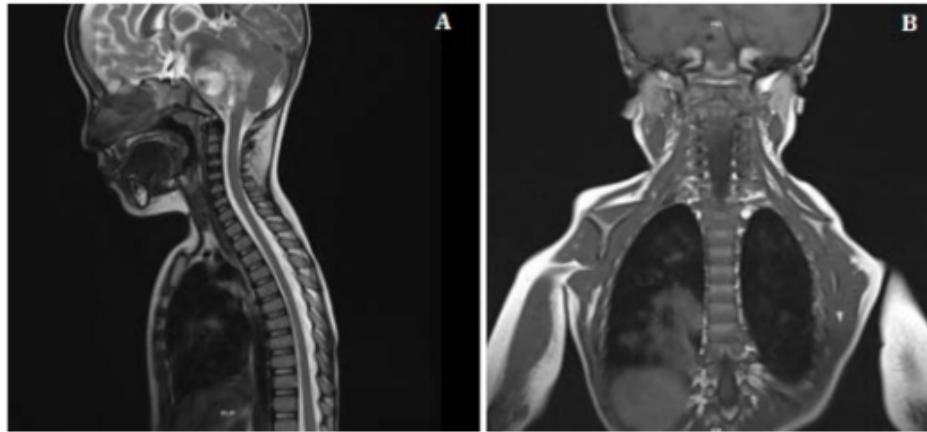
Postoperative contrast-enhanced cervical spine MRI. Panel A shows the sagittal view and Panel B the coronal view, demonstrating postsurgical soft-tissue changes, adjacent fluid collection, and partial visualization of a residual mass on the right side
